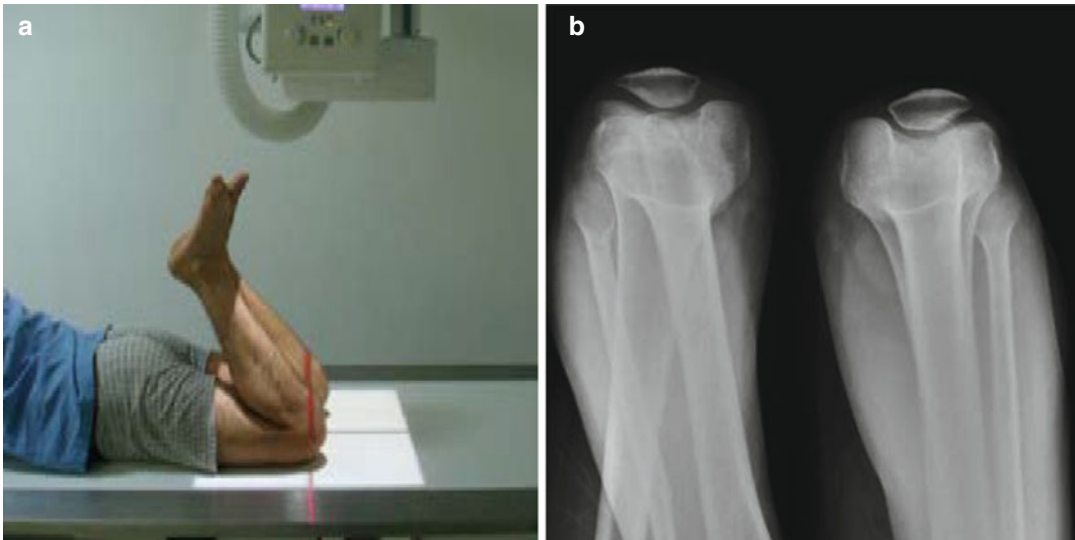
Position of the patient and x-ray during the knee tangential graph
